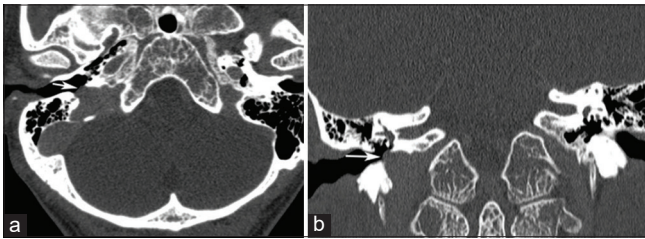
A 29-year-old man with jugular bulb dehiscence. (a) Axial post-contrast high-resolution computed tomography image with coronal multiplanar reformation (b) shows presence of a small bony defect involving the jugular plate with herniation of the jugular bulb in to the middle ear (arrows), consistent with jugular dehiscence.
